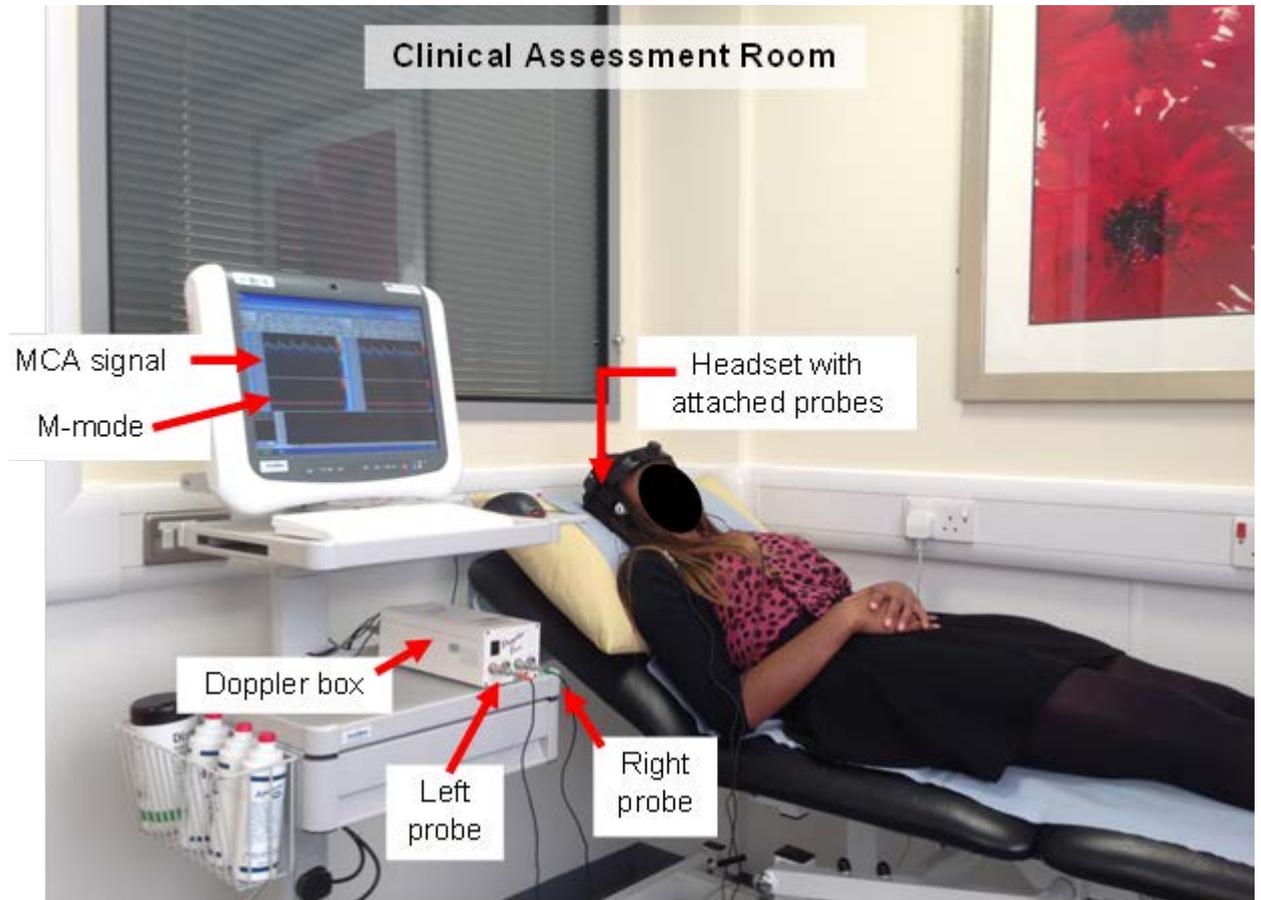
TCD ultrasound setup in the clinical assessment room available within the Leicester Cardiovascular BRU.
